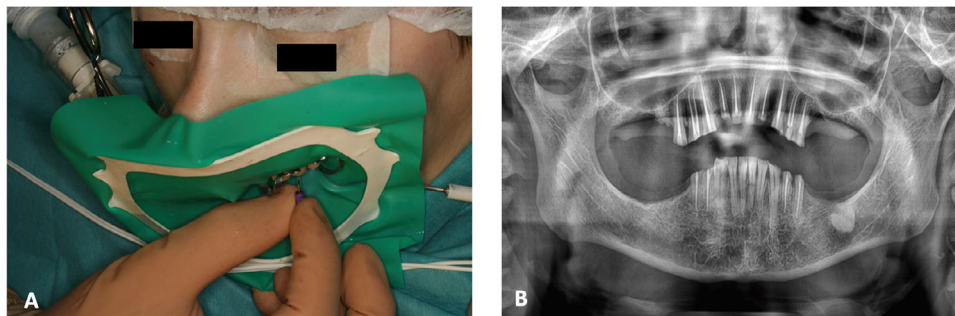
(A) Details of the endodontic procedure performed under general anesthesia, and (B) The final panoramic radiograph obtained after completing the extractions, root canal treatments, and restorations.
